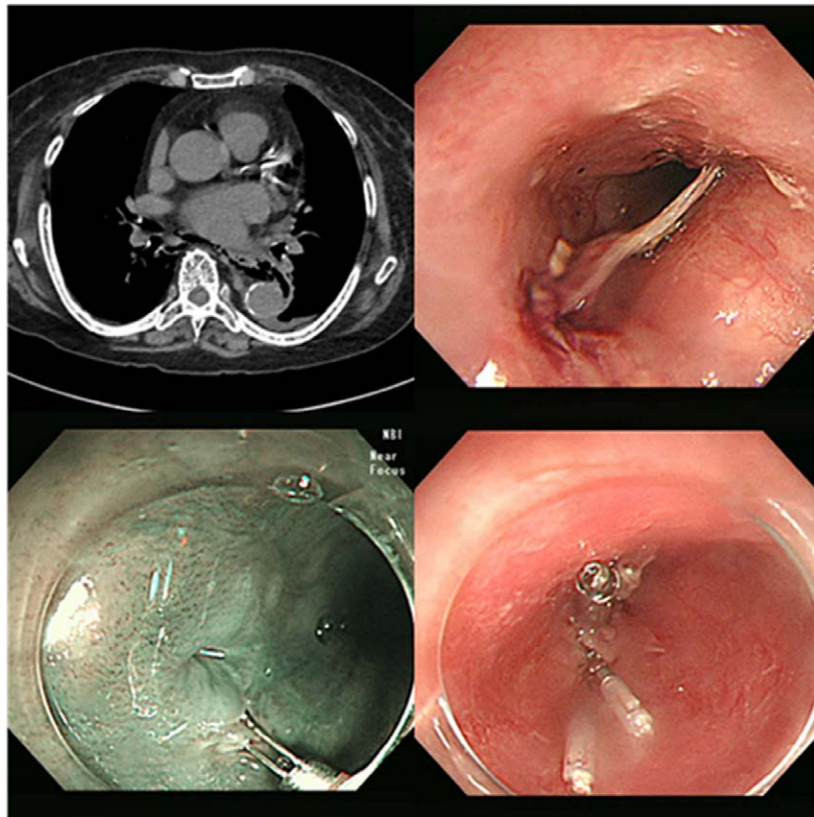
The case of esophageal perforation. It was diagnosed via computed tomography and treated with hemoclip closure.
